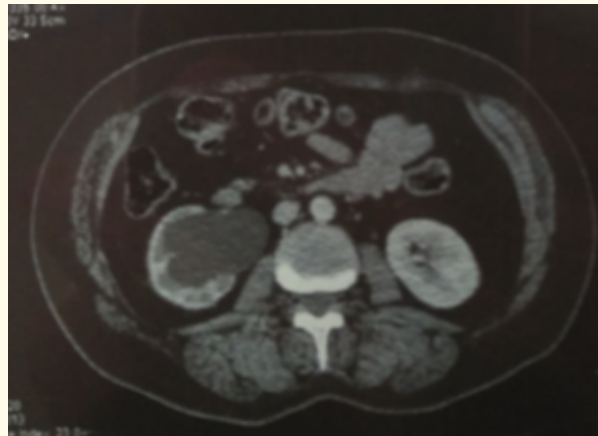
Abdominal CT-scan revealing uretero hydronephrosis.
